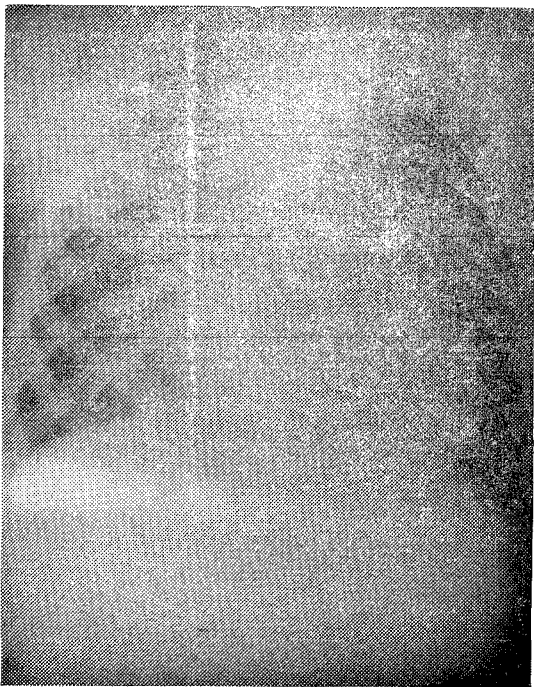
X-ray chest shows calcification in both lung fields.
